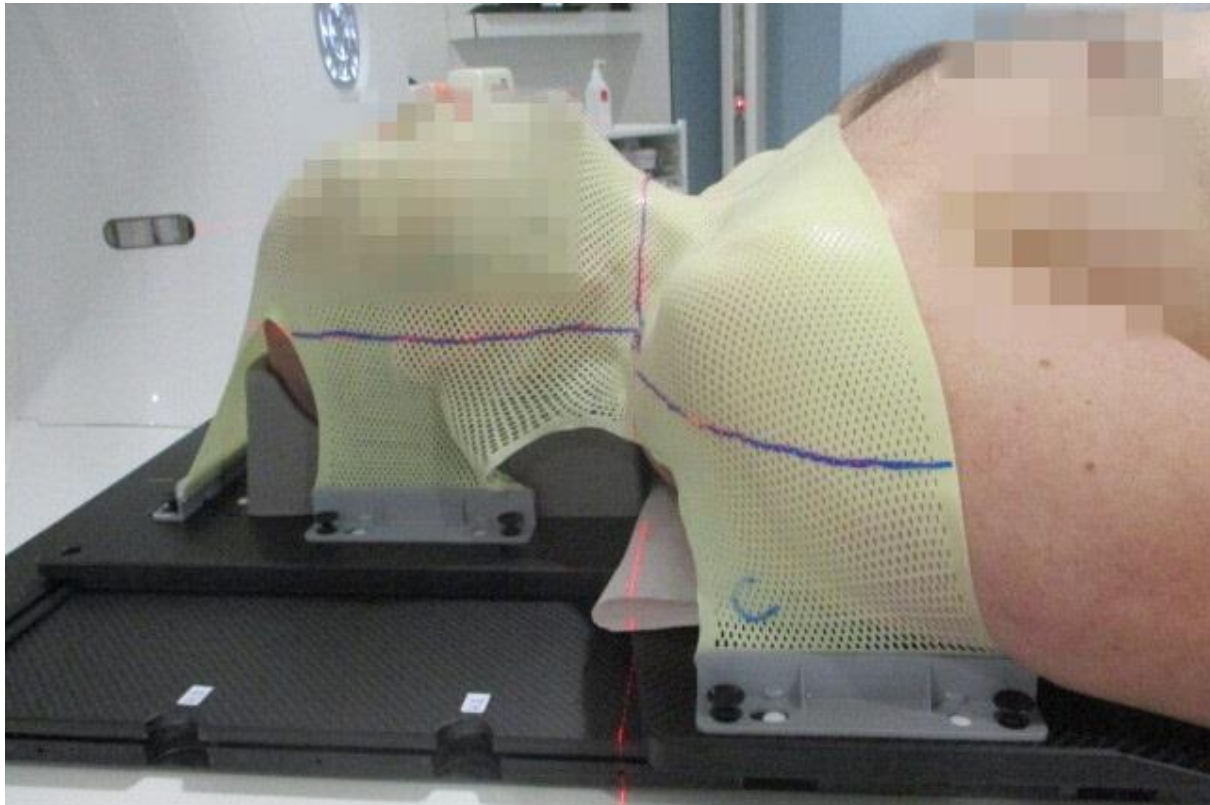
Picture of a patient with head-and-neck cancer during acquisition of the planning CT. A 5-points thermoplastic mask, molded around the patient's body outline, is used for stable and reproducible patient positioning. The localization point is marked on the mask as a reference for patient setup during each treatment session. Patient-specific characteristics have been censored for reasons of privacy.
